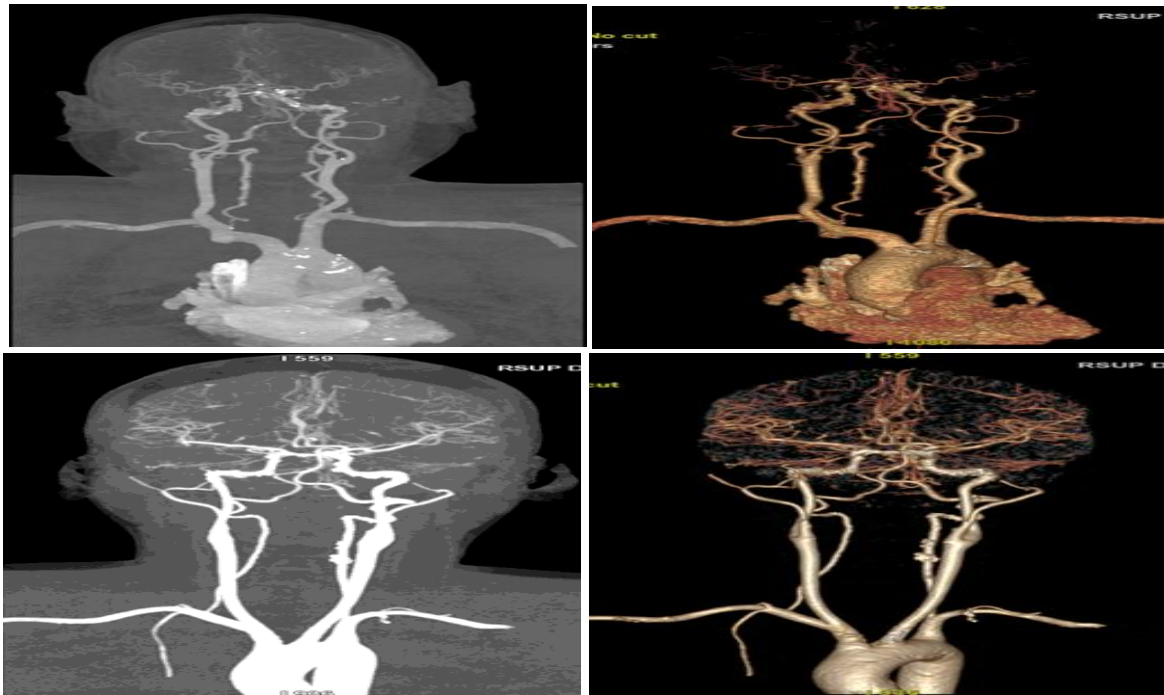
The results of cerebral carotid angiography CT images (top) represent images at a tube voltage of 100 kVp (standard) and (below) low kv images at a tube voltage of 70 kVp showing Maximum Intensity Projection (MIP) images and 3D VR images
